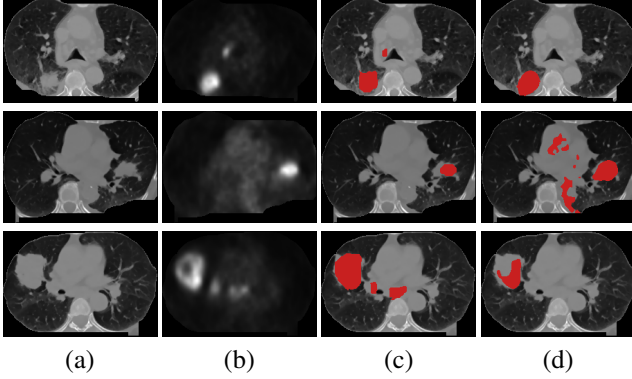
Comparisons of detection outputs, with each row showing one example. (a) CT image slices. (b) Co-registered PET image slices. (c) Detection outputs of our proposed method, with abnormalities highlighted in red. (d) Comparison outputs, with top row showing the result from [7], and middle and bottom rows showing the results using SUV 2.5 and 50% maximum SUV as the thresholds respectively.
